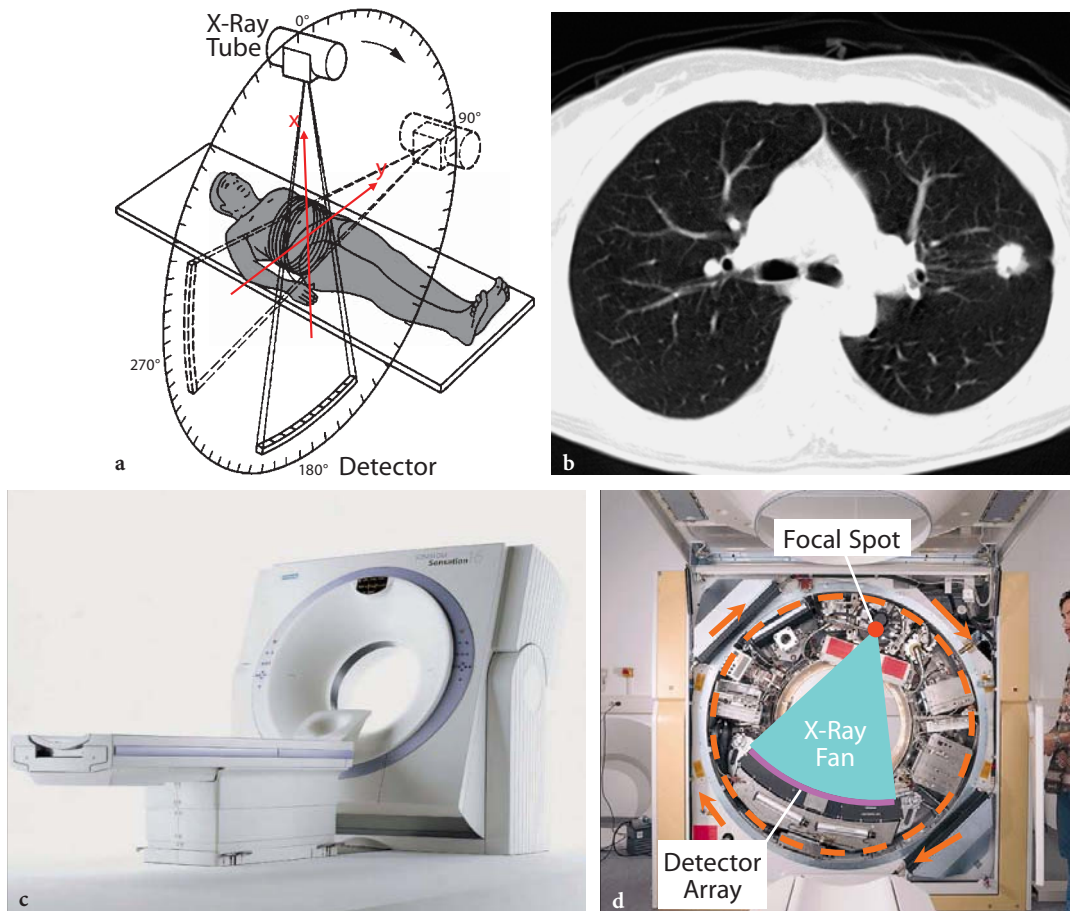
a X-rays emitted by the X-ray tube in the form of a fan beam pass through the cross-section of the patient, who is located within the scan field of view. The image plane is defined with the two spatial coordinates x and y . b Projections are acquired from 1000–2000 different positions of the X-ray source to construct a cross-sectional image of the scanned anatomy, e.g., of the chest. Within the chest, the lung tissue, which has low attenuation, is displayed in dark shades; the bronchi, mediastinum, lung lesions, and the ribs have high attenuation and appear as bright areas. Within the CT system (c), the tube and detector are mounted on a fast-rotating mechanical system, called a gantry (d)
